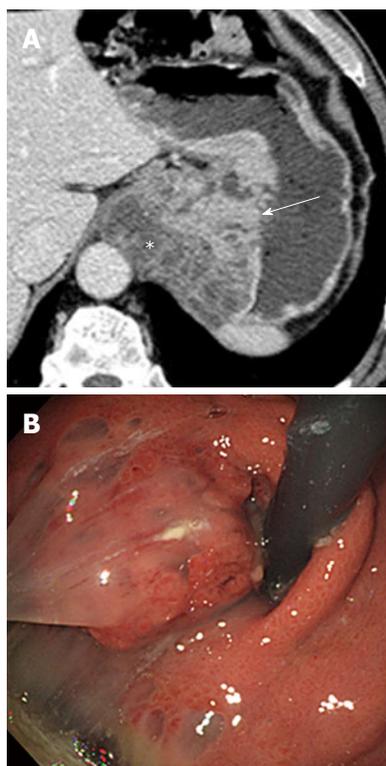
Mucinous carcinoma of the stomach in a 62-year-old woman. A: Contrast-enhanced CT image shows a large mass lesion in the gastric cardia containing abundant mucin pools (asterisk) and enhanced solid portions (arrow); B: Endoscopy image shows jellylike mucin leaking from the gastric mass. CT: Computed tomography.
